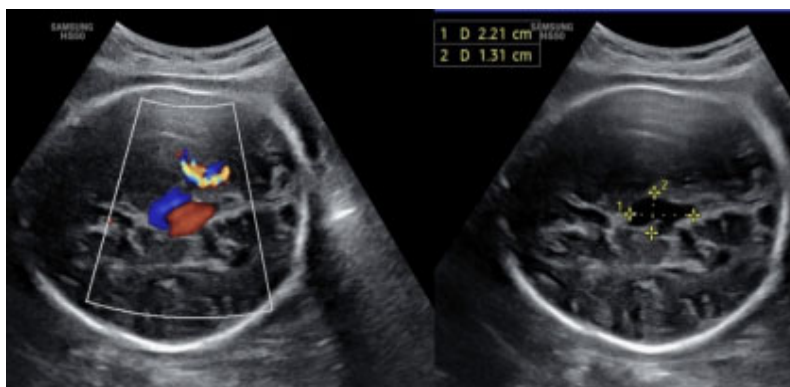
Antenatal ultrasound image of vein of galen
